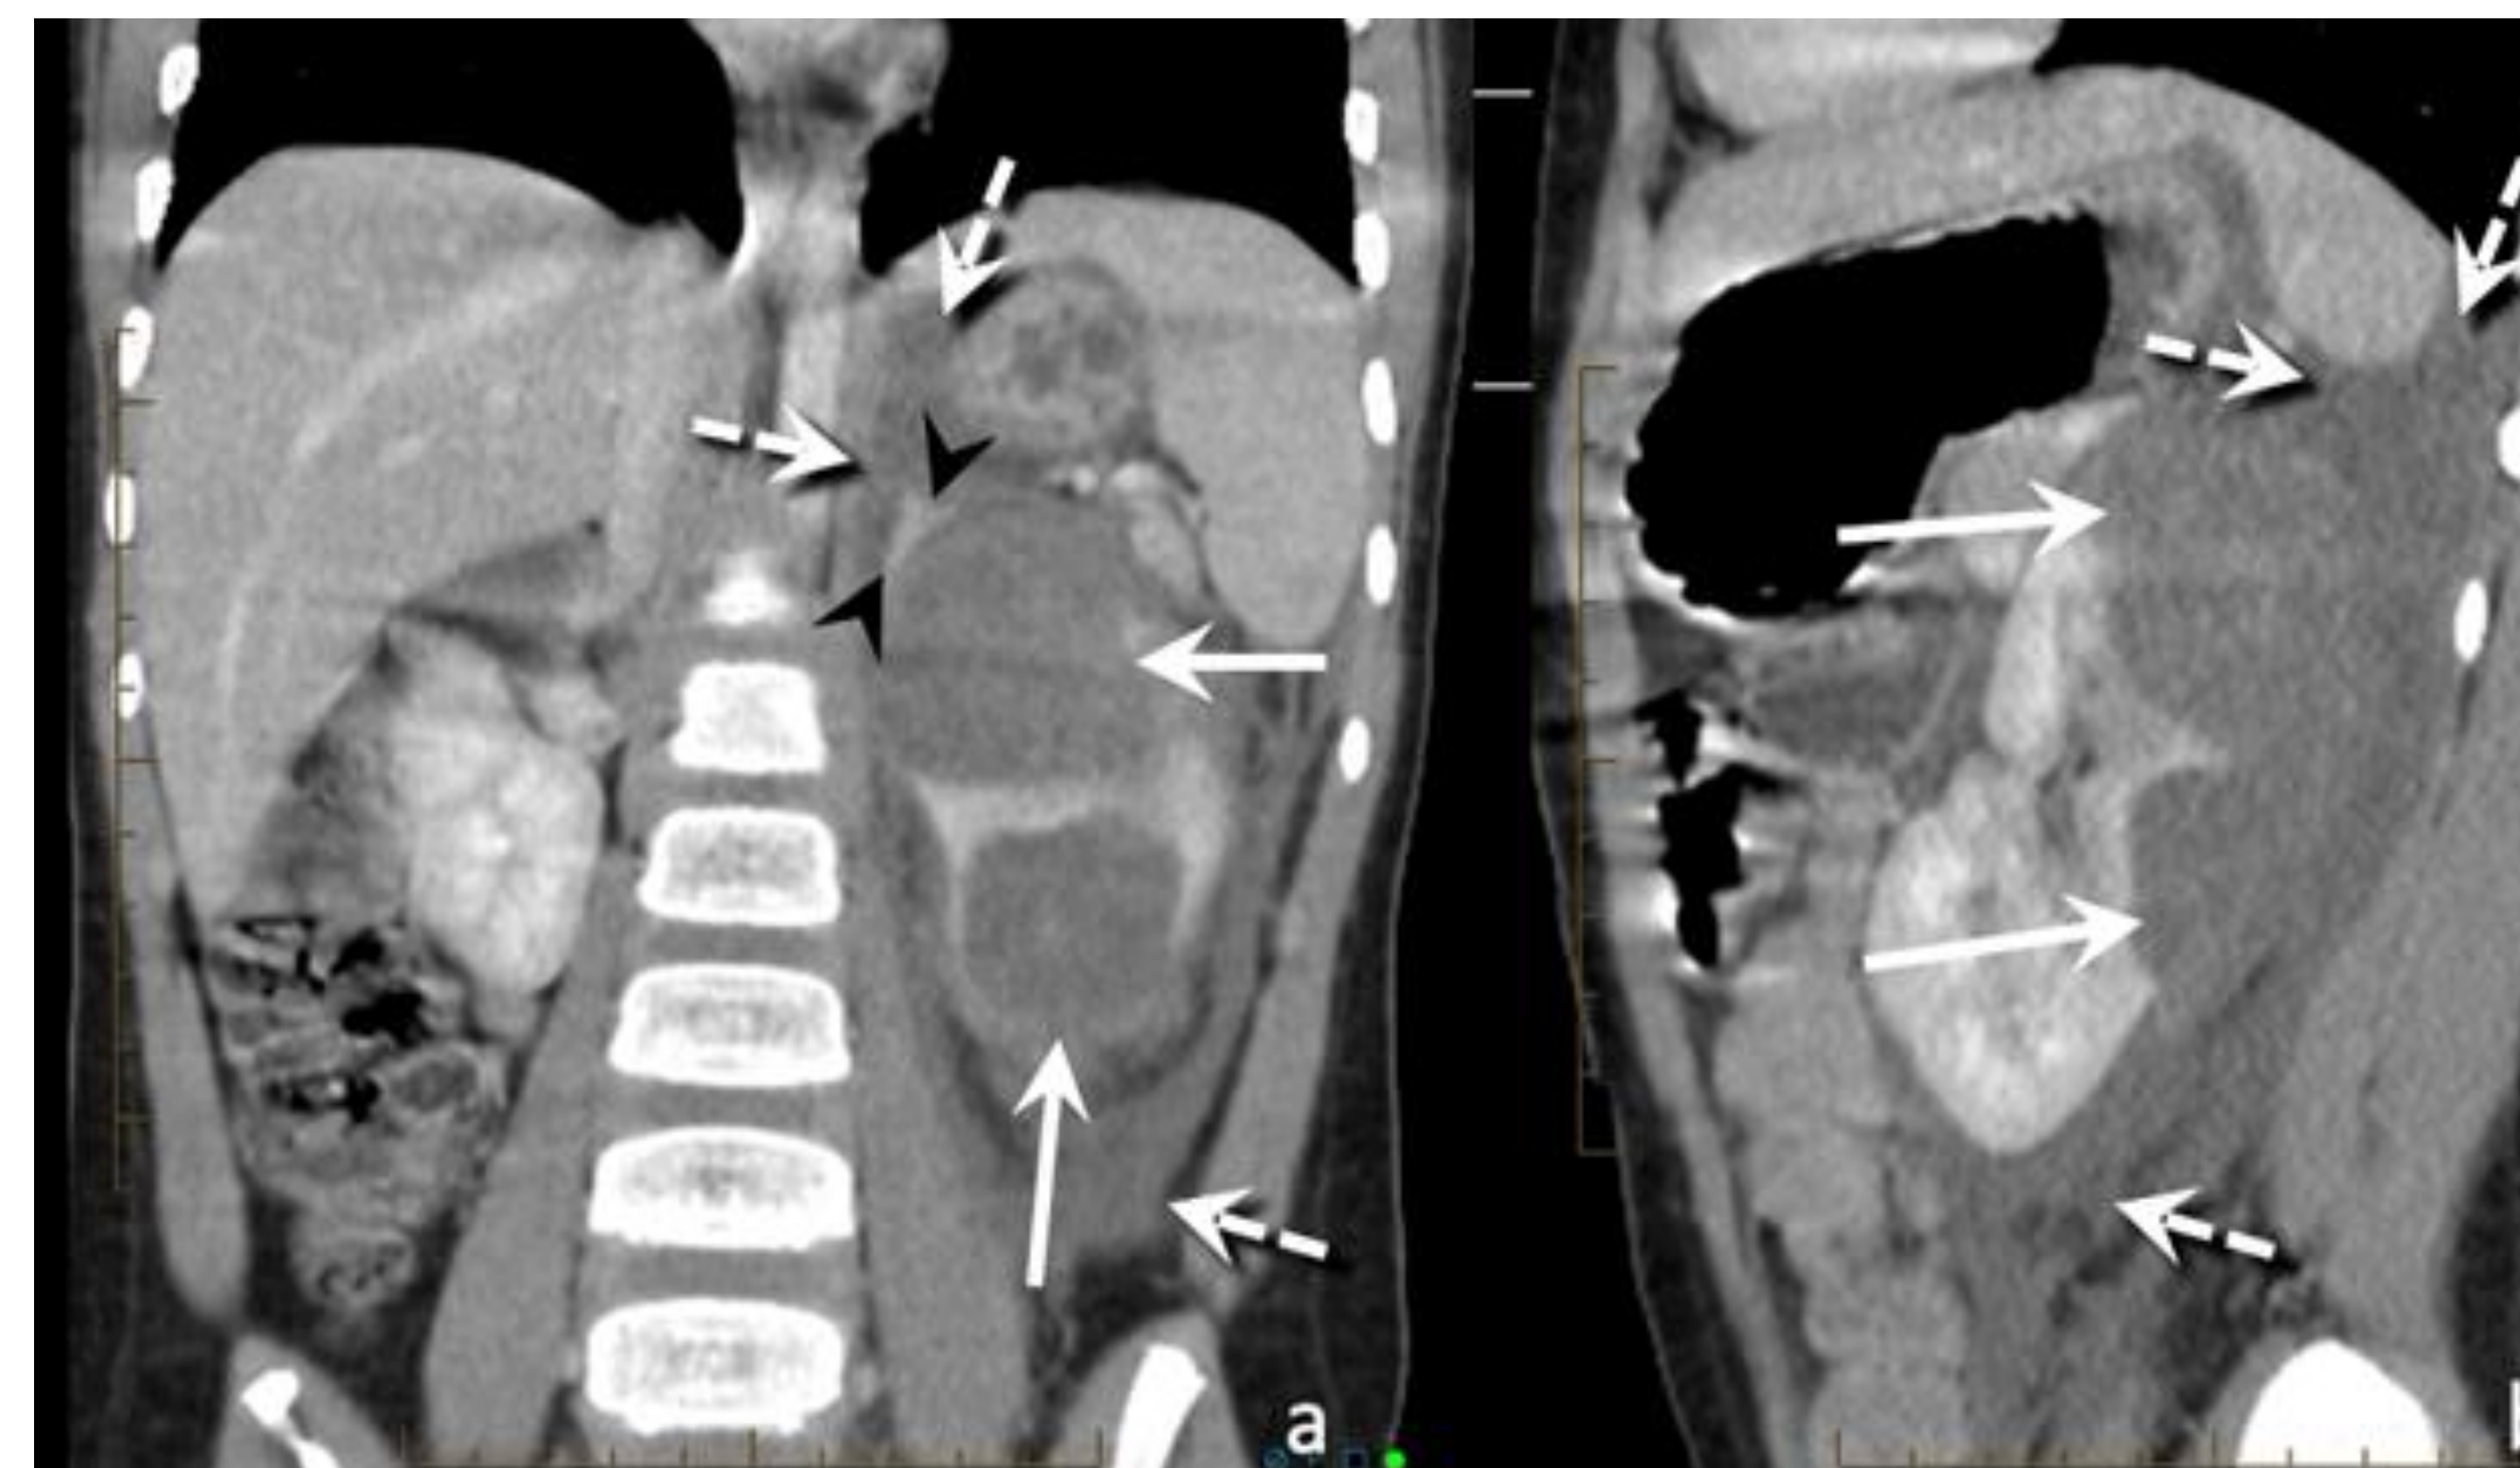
Coronal (a) and sagittal (b) contrast-enhanced CT images from initial study show the lobular renal mass (white arrows) and perirenal fluid or hemorrhage (dashed white arrows) that surrounds the adrenal gland (black arrowheads).
